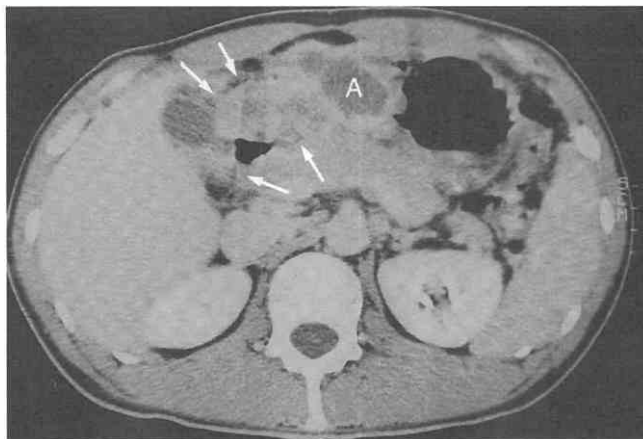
Confined peptic ulcer perforation. CT scan shows a perigastric cystic mass (A) with a thick peripheral wall in the perigastric region. The wall of the stomach and duodenum is considerably thickened with heterogeneous contrast enhancement (arrows) and evidence of perigastric infiltrates is present.
